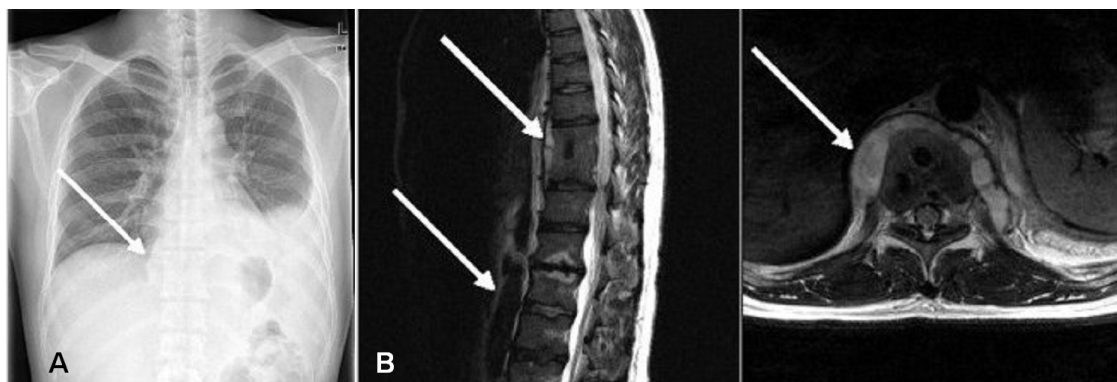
Chest PA (A) on admission shows a paravertebral mass and left pleural effusion (arrow). A magnetic resonance image (B) shows congenital block vertebrae in T10–T11, paravertebral abscesses and retroperitoneal fluid collection (arrows).
